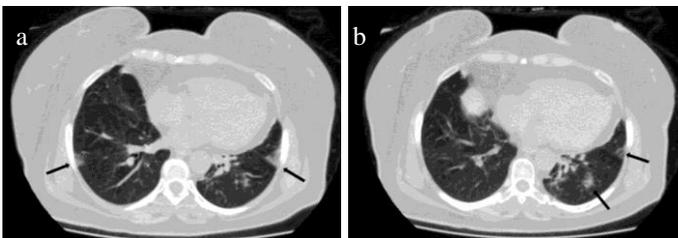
61-year-old female patient who presented with nausea and gastric pain. Axial abdominopelvic CT images with lung windows (a, b) demonstrate bilateral peripheral located ground-glass opacities and nodules (arrows). After abdominal CT findings raised concern for COVID-19, the patient was found positive for coronavirus disease.
